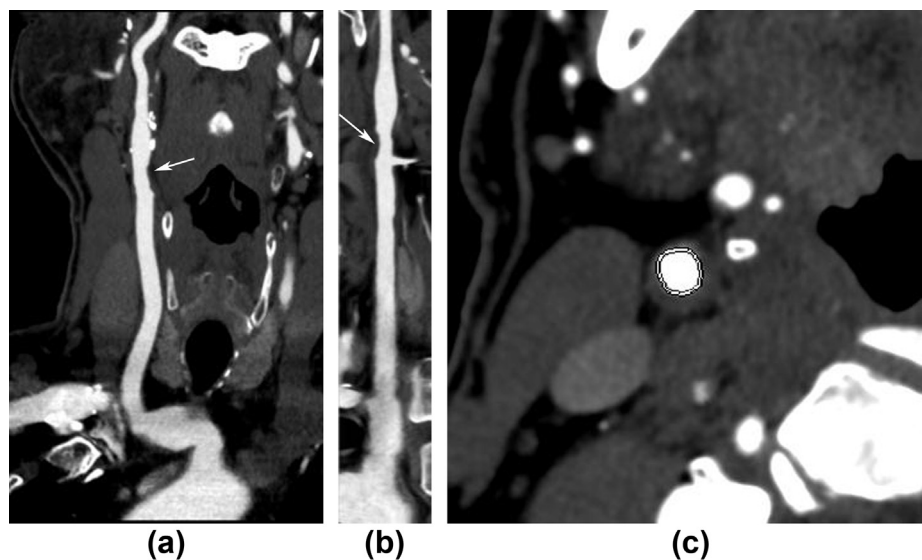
CTA images of a 58-year-old man using 175 mg iodine/kg, 80 kV, and 600 mA. (a) MPR image clearly displays the soft plaque in the right internal carotid artery. (b) Vascular image clearly shows the multi-soft plaque in the right common carotid artery. (c) Axial image clearly displays the soft plaque of the right internal carotid artery.
